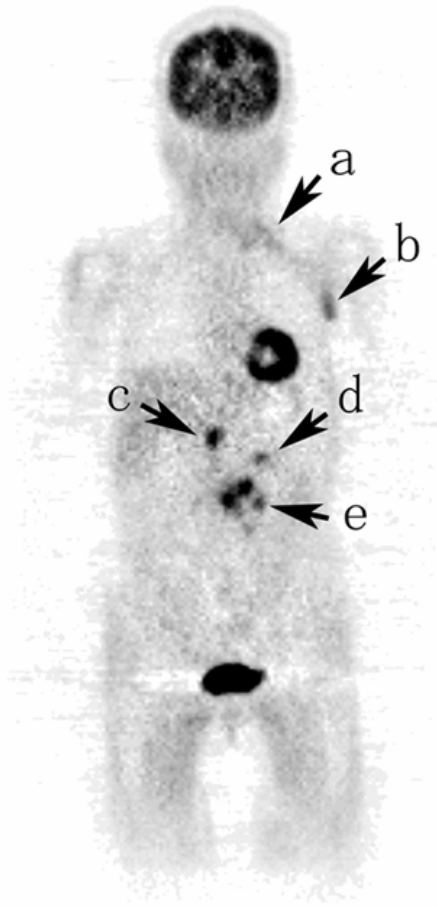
The image of FDG PET has accumulations corresponding to all lesions. The arrow (d) indicates the slightly high accumulation of FDG that is thought to be corresponding to the primary lesion. All other high accumulations of FDG are corresponding to the metastatic lesions in; a: the cervical lymph nodes. b: the axillary lymph node. c: the retropancreatic lymph node. e: the para-aortic lymph nodes.
